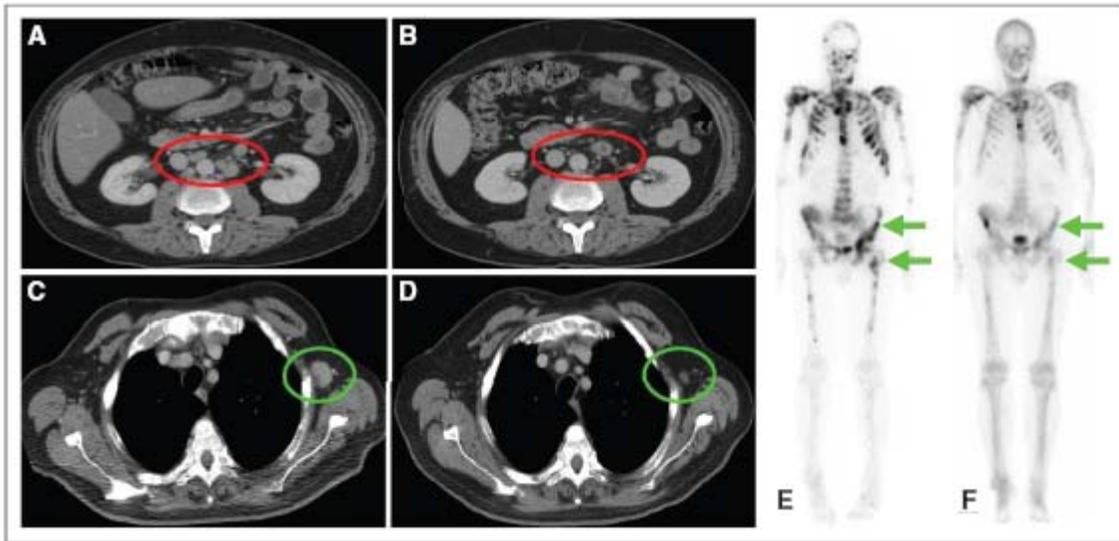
Radiologic responses. (A) Patient 010 had previously experienced progression on an luteinizing hormone-releasing hormone (LHRH) agonist, flutamide, bicalutamide, docetaxel, the monoclonal antibody to IGF-1R, CP-751, 871, and the survivin inhibitor YM155. Before starting treatment with abiraterone acetate, the prostate-specific antigen (PSA) was 799, and there was evidence of nodal and bony metastatic disease. Circulating tumor cells (CTCs) were not detected. Red oval, retroperitoneal nodal disease on a baseline computed tomography (CT) scan (A). After 3 months on abiraterone acetate, PSA decreased to a nadir of 1.4 (ie, > 90% decline), and (B) the red oval shows that the nodal disease has largely disappeared. Patient 010 continues to take study drug, now in the third year of treatment. (C) Patient 025 had previously experienced progression on an LHRH agonist, antiandrogen, stilboestrol, and docetaxel. Baseline PSA was 10,325, and it decreased to a PSA nadir of 46 (ie, > 90% decline) after 4 months on abiraterone acetate. Baseline CTC count was 20, which decreased to a CTC count nadir of 0 after 4 weeks. Green oval, CT scan at baseline demonstrated an axillary nodal metastasis (C). Reduction in size is seen in a follow-up scan performed at 6 months (green oval; D). (E) Whole-body, ^{99m}Tc-MDP bone scintigraphy at baseline (again for patient 025). A response in the bony disease can be seen in (F) after 6 months on abiraterone acetate. This patient remained on study in excess of a year (ie, 482 days).
